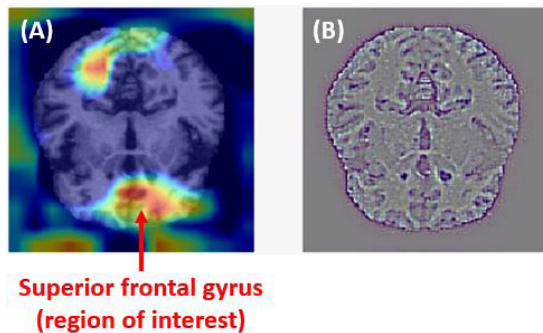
Region of interest (ROI) using Kaggle data showing the superior frontal gyrus (SFG) on the brain axial MRI images of the VGG-16 data. (A) with ROI and (B) without ROI. Red color shows the accurate location of the ROI.
